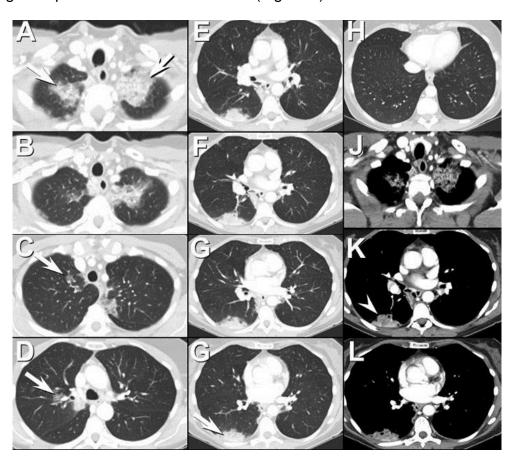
Axial enhanced chest CT displayed in lung (A-H) and soft tissue (J-L) windows.
